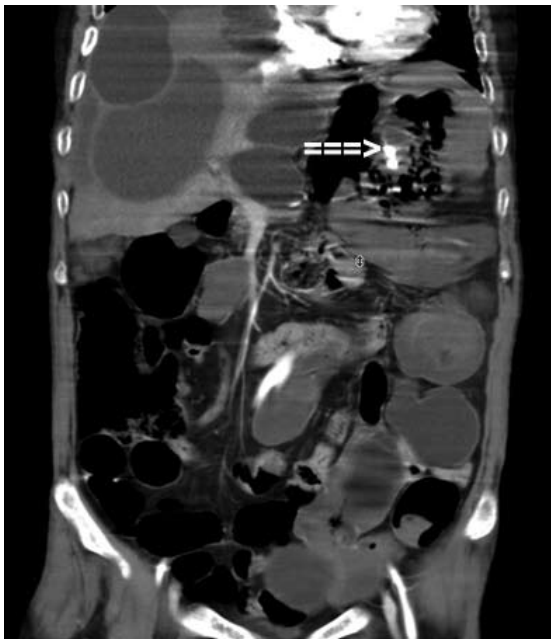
Contrast-enhanced reconstructed coronal abdominopelvic CT image shows active extravasation of contrast agent from the splenic hilus into the colon's splenic flexure (arrow). This confirms communication between the splenic hydatid cyst and colon. Note multiple cystic lesions in the abdomen and pelvis.
